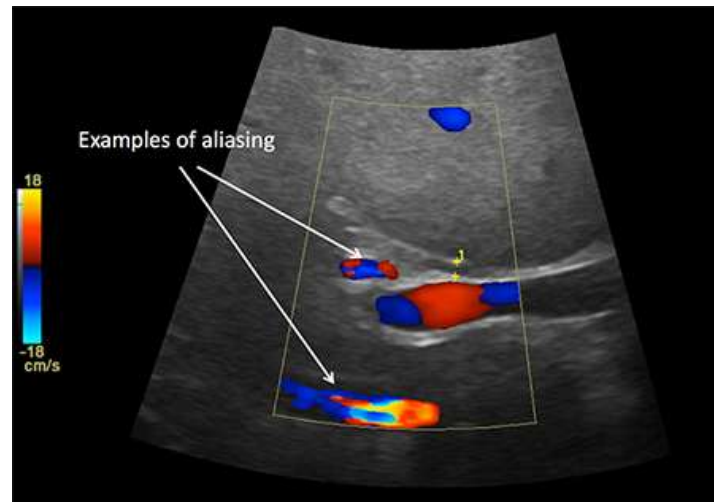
21. 11. Aliasing Artifact in Doppler USG
